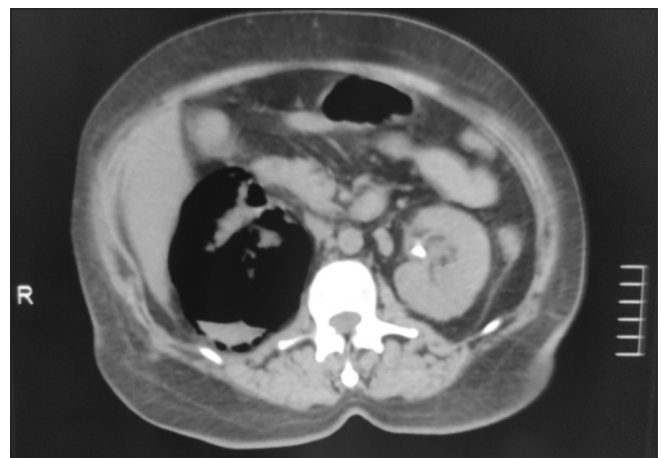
Class 3 EPN (CT KUB plain)
